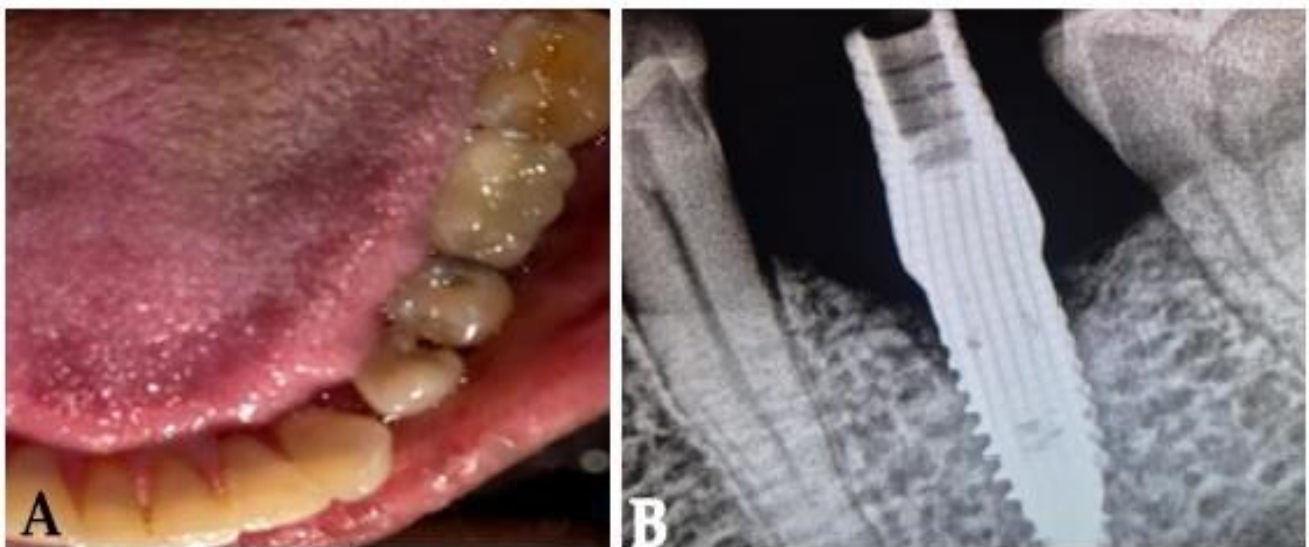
Six-month postoperative clinical (A) and radiographic (B) views showing stable peri-implant conditions and maintenance of the grafted ridge.
